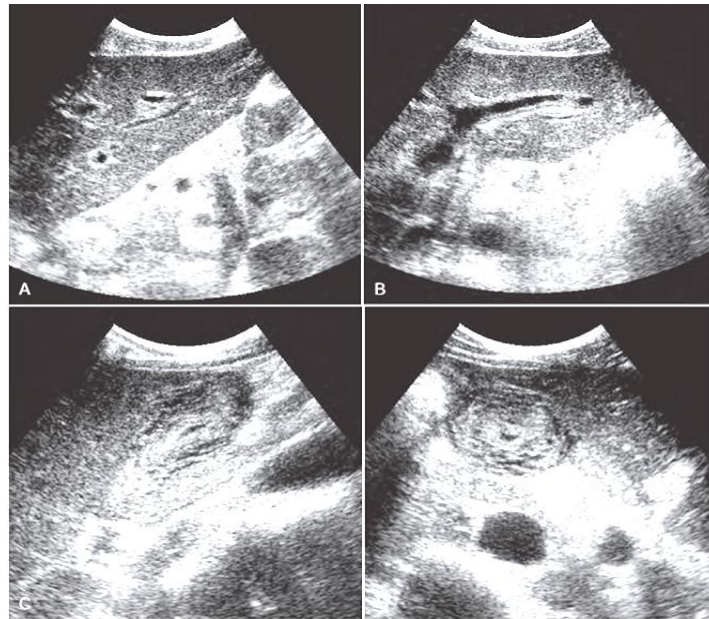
Ultrasound images A, sagittal and B, transverse, images of the left lobe of the liver show marked increased thickness and echogenicity of the soft tissue surrounding the portal vein branch. C, sagittal and D, transverse, views of the thickened gall bladder wall with extensive hypoechoic pocket of edema fluid.(Carol, 2011)
